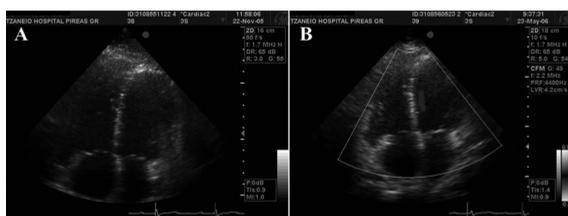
Comparison of preoperative (A) and postoperative (B) echocardiogram in a patient with RV dilatation depicting the postoperative decrease in RV dimensions.
